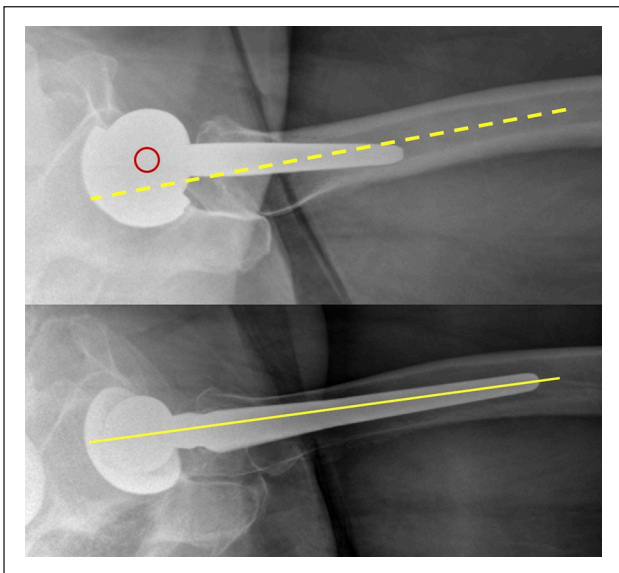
Radiographs demonstrating translation of the centre of rotation posteriorly with a long femoral stem in comparison to the Preserve stem.
